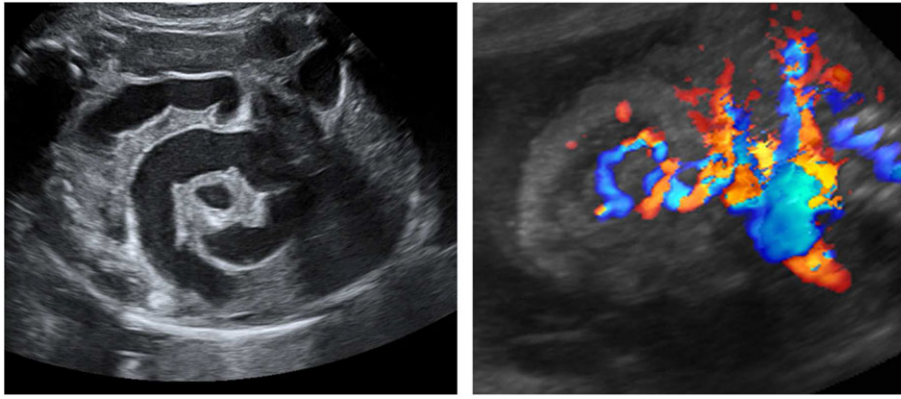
Case #2, 26 weeks of gestation. Prenatal midgut volvulus: Ultrasound features: whirlpool sign (axial ultrasound image in 2D and color Doppler) [Colour figure can be viewed at wileyonlinelibrary.com]
